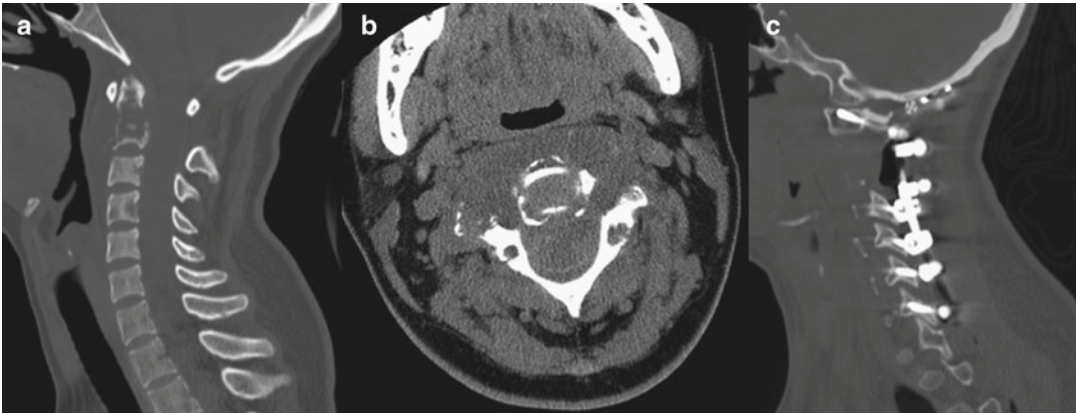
Sagittal CT (a) shows tumor destroying C2. Axial CT (b) shows tumor involvement at C2. Post-operative sagittal CT (c) study shows resection of the C2 body and placement of hardware
